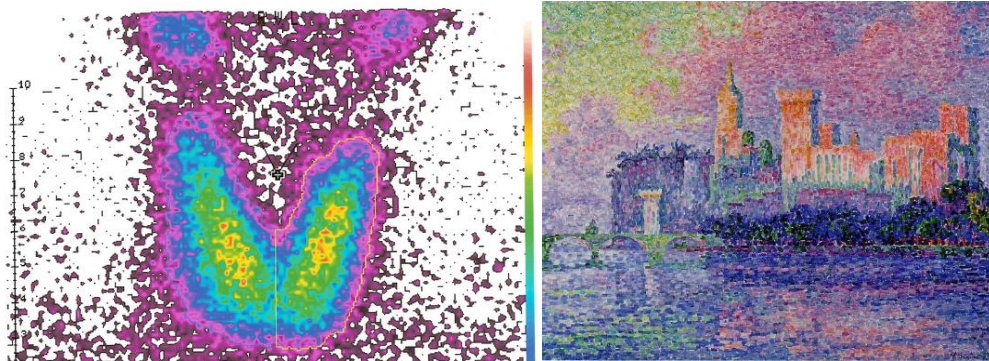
Links: Szintigramm einer gesunden Schilddrüse mit Technetium-99m-per-technetat als Radiotracer in einem SPECT [16]. Rechts: Der Papstpalast zu Avignon von Paul Signac derzeit ausgestellt in Musée d'Orsay, Paris, Frankreich.
